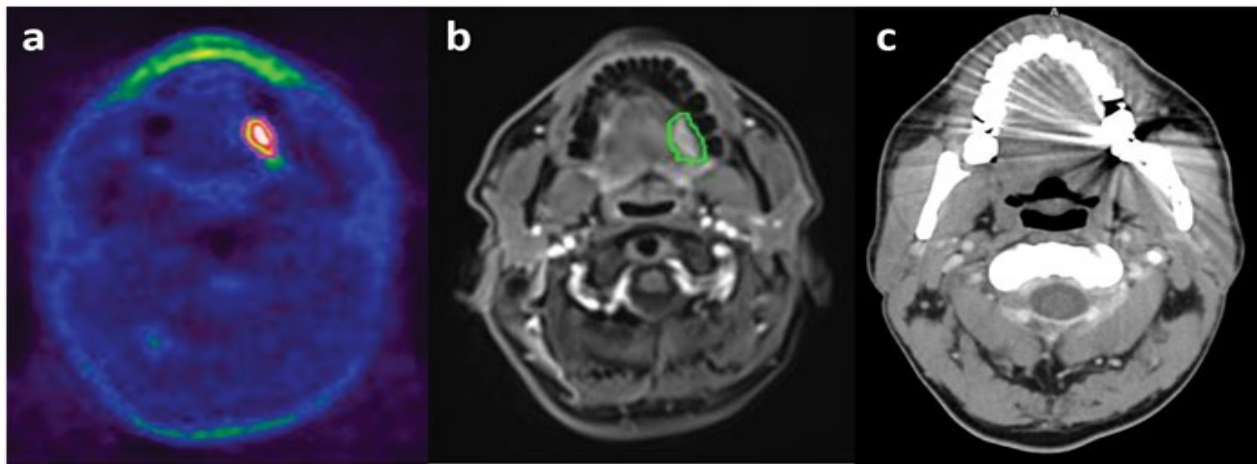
Patient with squamous cell carcinoma of the base of the tongue (T3N0M0) and dental restoration in the left second molar tooth. Primary tumor volume delineated with the manual method and presented on: (a) 18-Fluor-labelled Fluorodeoxyglucose Positron Emitted Tomography (PET) image (pink line), (b) Magnetic Resonance (MRI) image (green line), (c) primary tumor volume is invisible on the Computed Tomography (CT) image due to extensive artefacts from dental restoration
